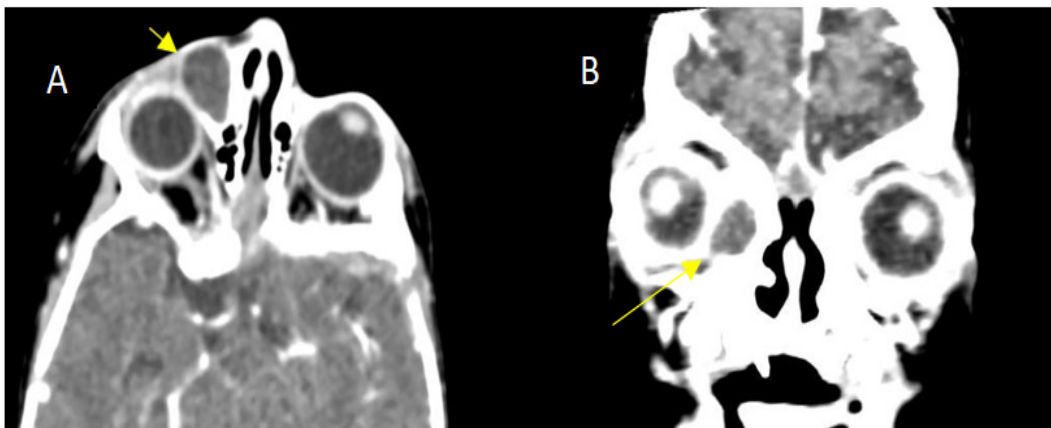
Axial (A) and coronal (B) facial CT scans post-contrast demonstrate peripheral enhancement of the medial canthal collection.
